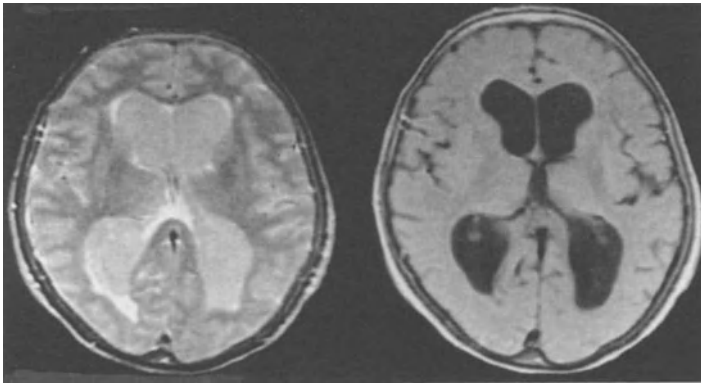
MRI of periventricular subependymal hyperintensity in acute hydrocephalus after subarachnoid haemorrhage, indicating transependymal CSF flow (see text)
